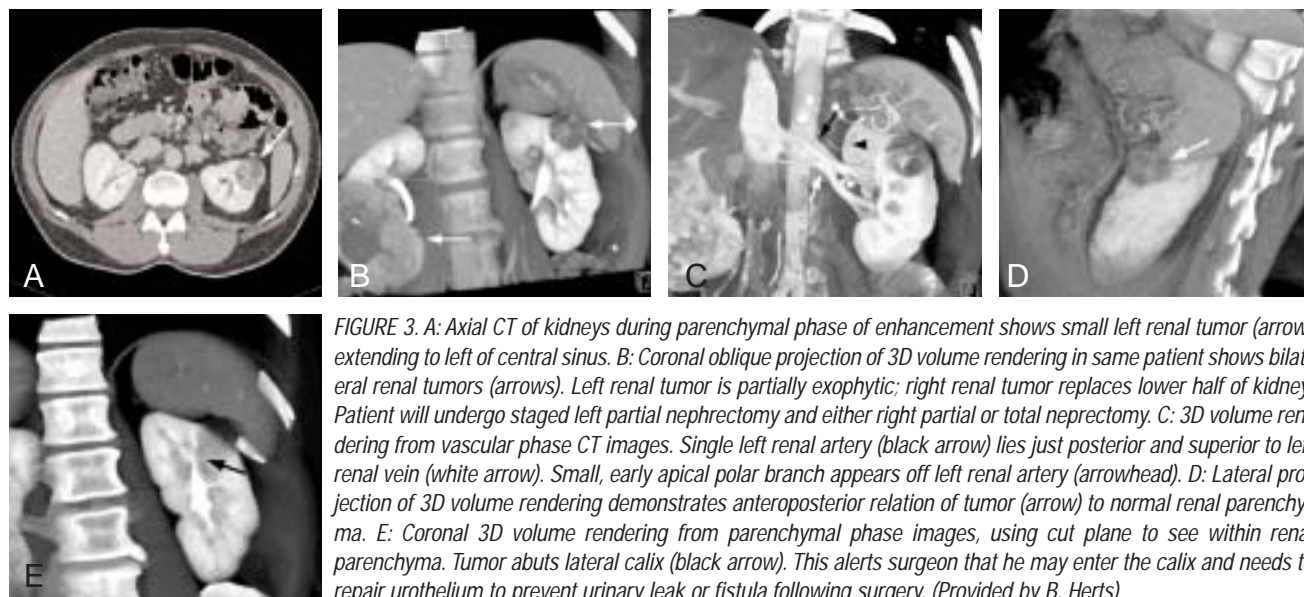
A: Axial CT of kidneys during parenchymal phase of enhancement shows small left renal tumor (arrow) extending to left of central sinus. B: Coronal oblique projection of 3D volume rendering in same patient shows bilateral renal tumors (arrows). Left renal tumor is partially exophytic; right renal tumor replaces lower half of kidney. Patient will undergo staged left partial nephrectomy and either right partial or total nephrectomy. C: 3D volume rendering from vascular phase CT images. Single left renal artery (black arrow) lies just posterior and superior to left renal vein (white arrow). Small, early apical polar branch appears off left renal artery (arrowhead). D: Lateral projection of 3D volume rendering demonstrates anteroposterior relation of tumor (arrow) to normal renal parenchyma. E: Coronal 3D volume rendering from parenchymal phase images, using cut plane to see within renal parenchyma. Tumor abuts lateral calyx (black arrow). This alerts surgeon that he may enter the calyx and needs to repair urothelium to prevent urinary leak or fistula following surgery. (Provided by B. Herts)
